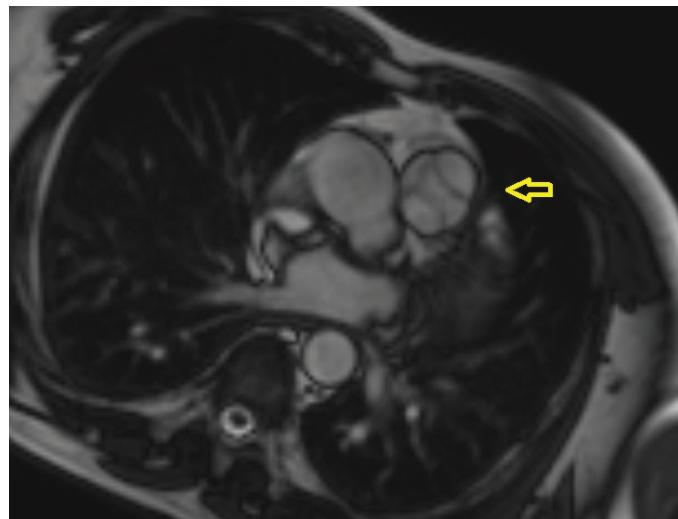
and Video 3. Cardiac magnetic resonance imaging showing the quadricuspid pulmonary valve (arrow).
